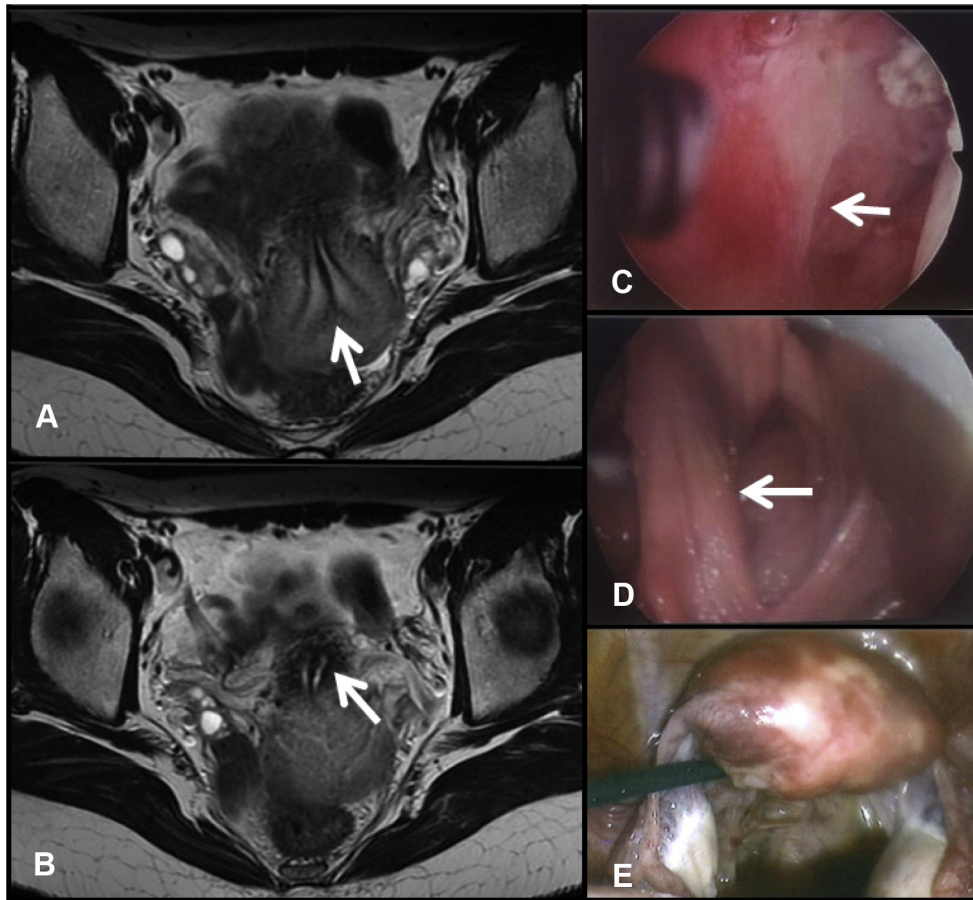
Images of Patient A. (A) Axial T2-weighted magnetic resonance imaging pelvis images showing a complete uterine septum (arrow); (B) a cervical septum (arrow); (C) hysteroscopic view of the uterine septum (arrow); (D) upper vaginal septum (arrow); and (E) laparoscopic view of the pelvis showing a normal uterine fundus.
